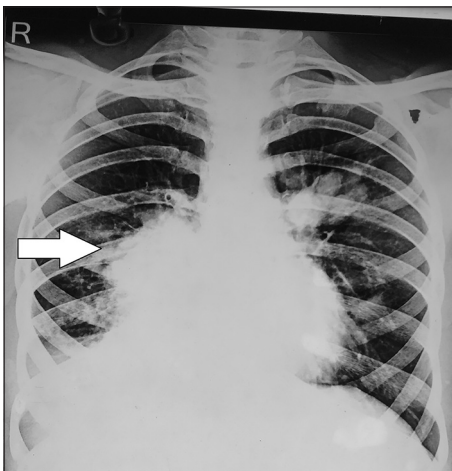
Chest X-ray posteroanterior view showing a mediastinal mass
